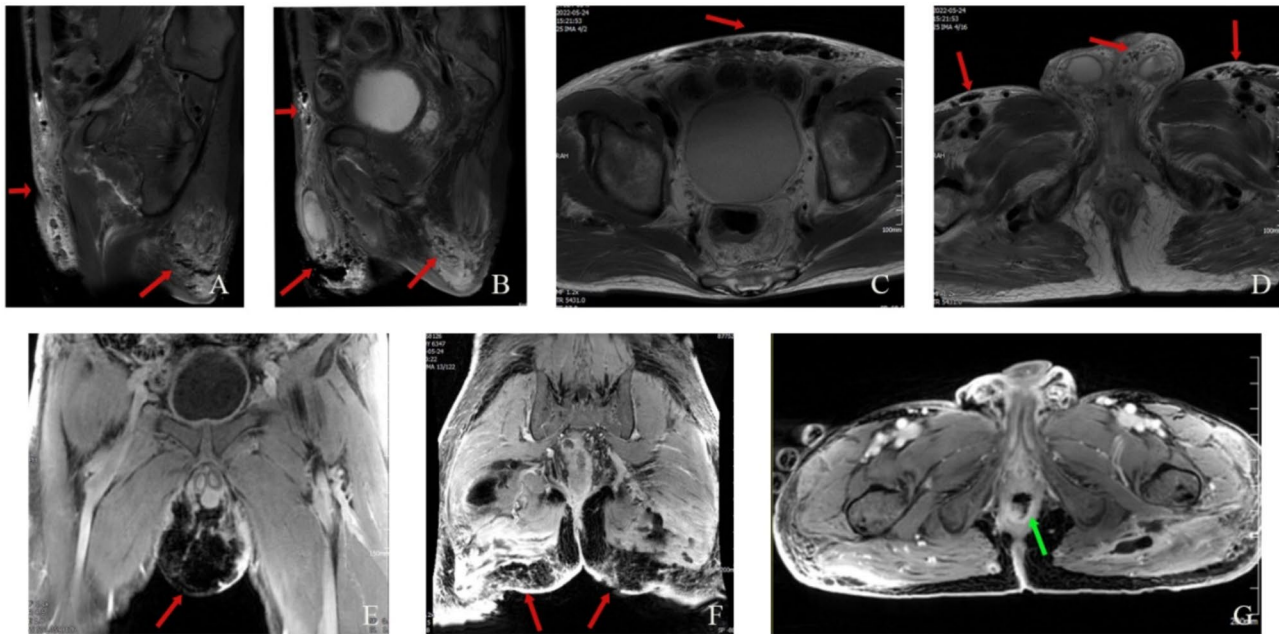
Representative images of MRI for the rectal cancer patient. (A, B) Sagittal, (C, D) axial and (E, F) coronal images of MRI showing large-scale soft tissue pneumatization as well as exudation in the abdominal wall, buttocks, and perineum. (G) Nodules on the posterior wall of the rectum adjacent to the anus, without evidence of rectal perforation
